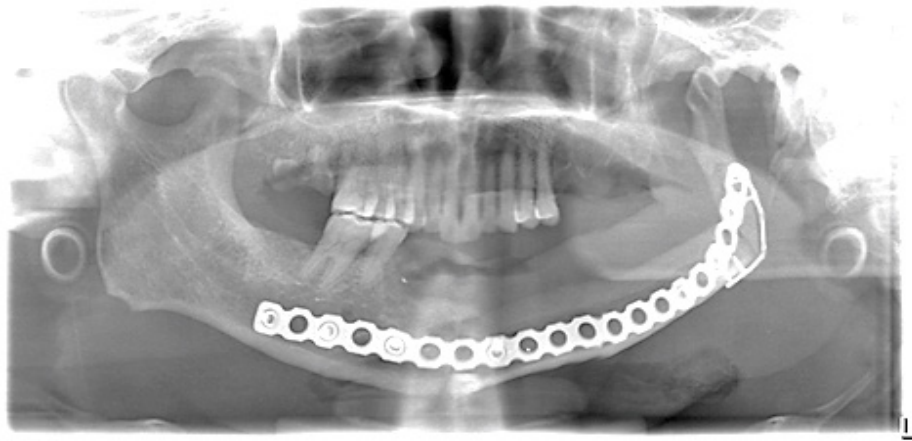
Postoperative X-ray(30th postoperative day).
